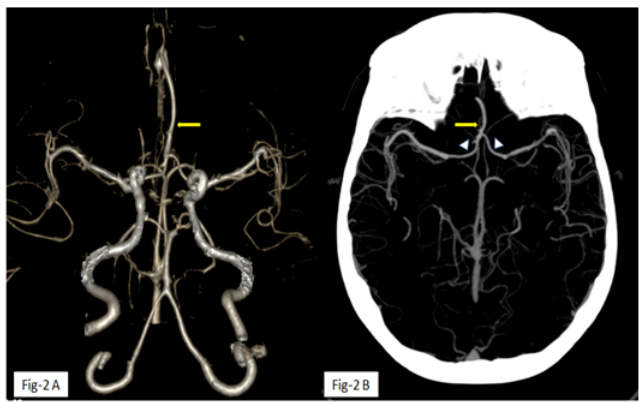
A, 3D cerebral CTA image and Fig-2 B, Axial cerebral CTA image showing the convergence of the bilateral A1 segments (white arrowheads) to form a single midline A2 trunk (yellow arrows) - Azygos anterior cerebral artery. It represents the persistence of the embryonic median artery of the corpus callosum.
